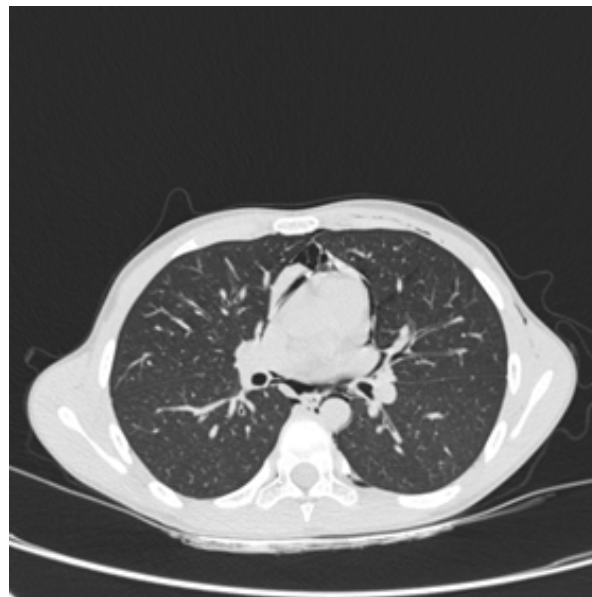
Chest CT (transverse section) showing hypodense material in the subsegmental bronchi of the lower lobes.
